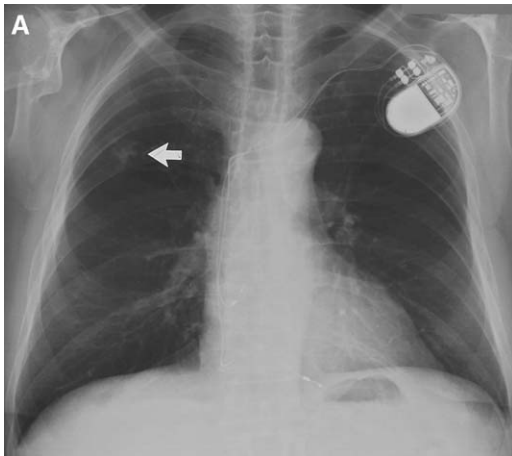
(A) Chest radiograph shows an irregular nodule in the right upper lung (*arrow*) that had increased in size from an examination 6 months prior. (B) FDG PET scan with coronal maximal intensity projection image shows no evidence of a hypermetabolic focus to correspond to the pulmonary nodule. Subsequent evaluation of the nodule showed it to be caused by coccidioidomycosis.
